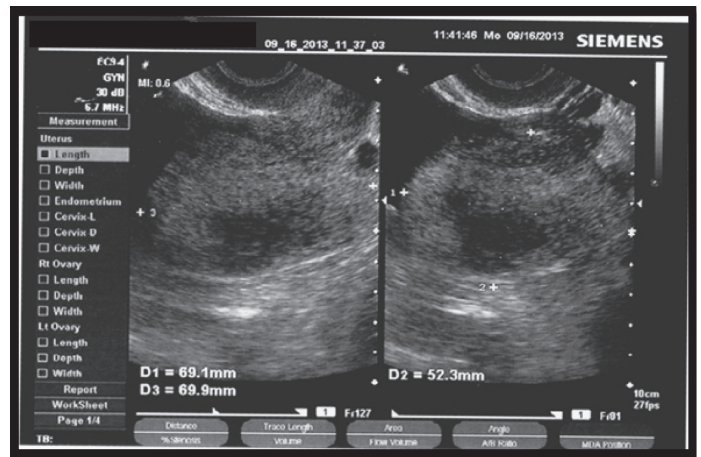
Transrectal ultrasound showing a left ovarian mass which was predominantly solid with areas of hypoechoicity, measuring 6.91 x 5.23 x 8.22 cm. This was signed out as Ovarian New Growth, left, probably malignant.
